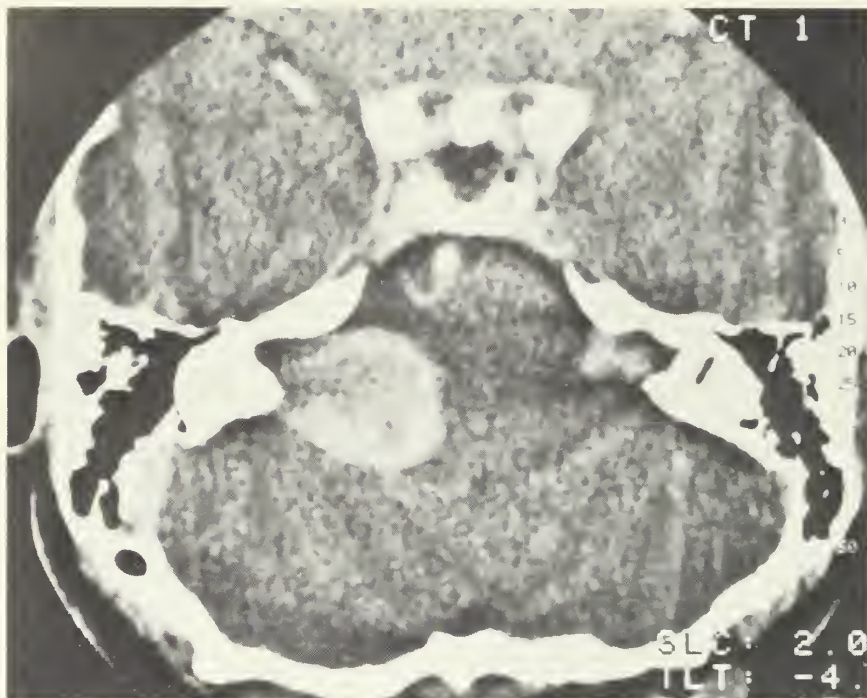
CT scan showing a large, enhancing, right acoustic neuroma, and a much smaller left acoustic neuroma.
